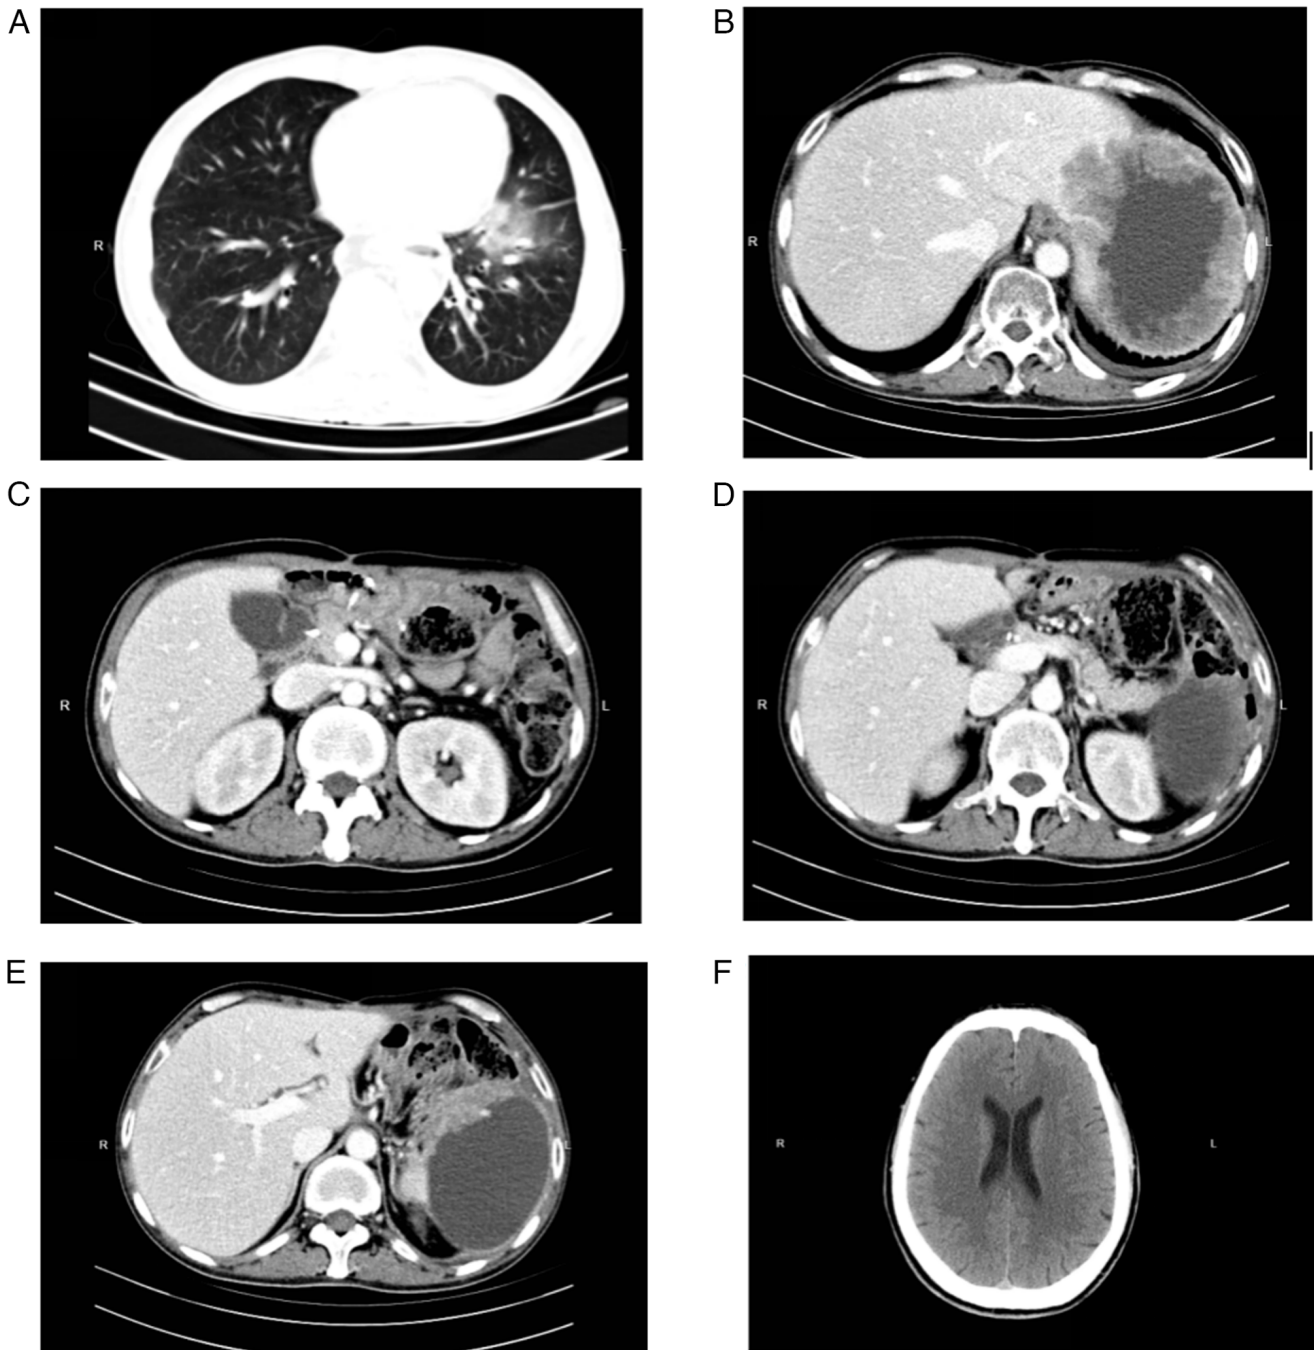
Representative CT scans showing a lack of metastasis. CT scan of (A) the lungs, (B) the liver, (C) the lymph nodes in the upper abdomen, (D) the head of the pancreas, (E) the body of the pancreas and (F) the brain. CT, computed tomography.
